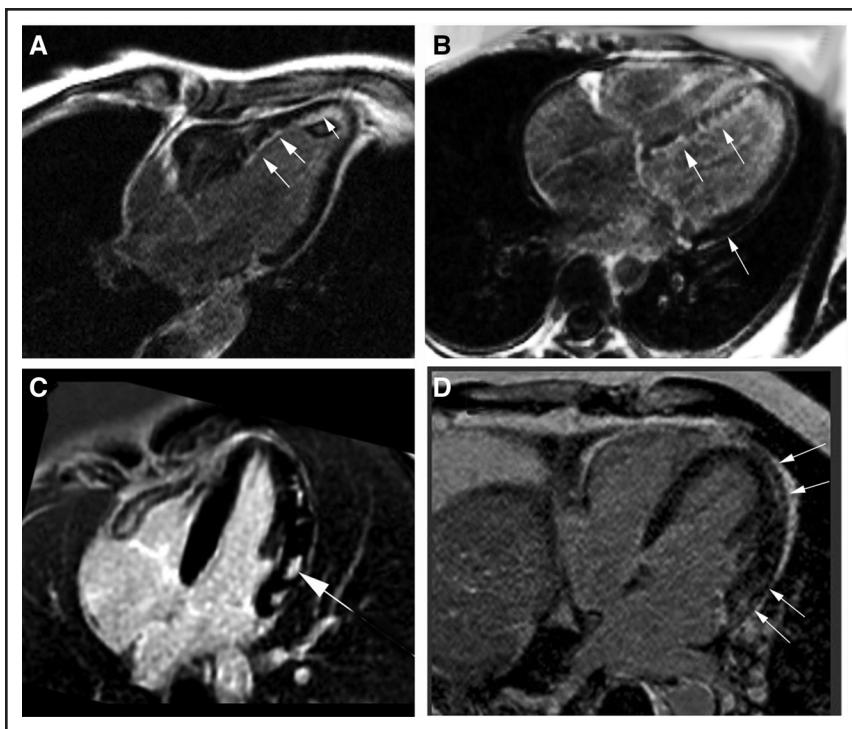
Myocarditis appears in different imaging forms as shown in this 4-chamber view of late gadolinium enhanced (LGE) cardiac magnetic resonance imaging (CMR) images.
